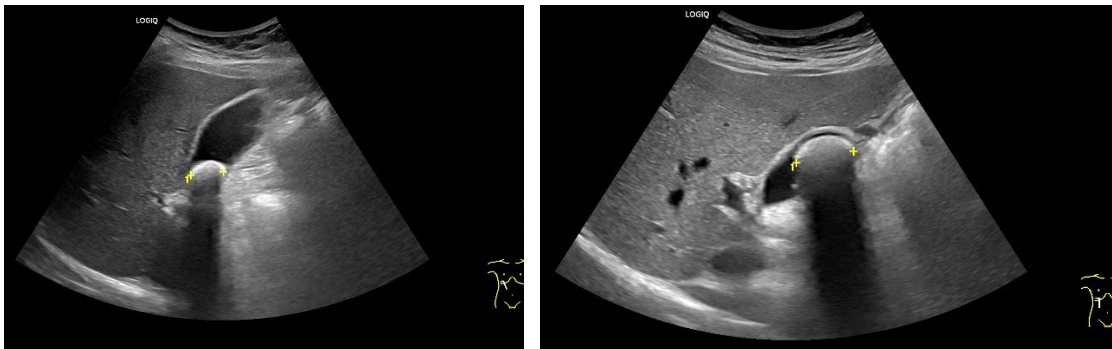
10. The ultrasound images show large gallbladder stones, hyperechoic (bright), with posterior acoustic shadowing.
